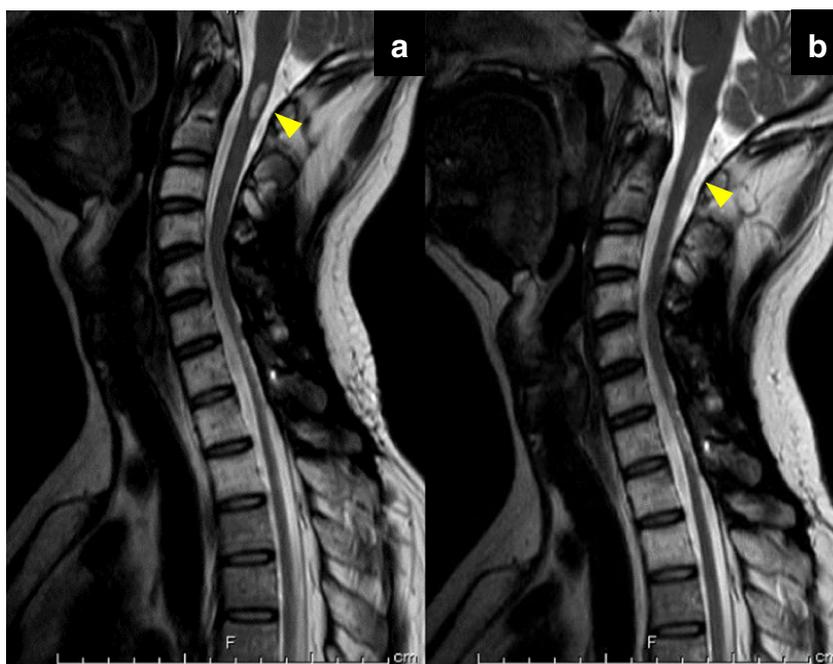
Magnetic resonance imaging showing a new bulbar lesion after alectinib discontinuation (a; sagittal plane view of T2-weighted image). Four months after alectinib rechallenge therapy, the lesion had disappeared (b; sagittal plane view of T2-weighted image). Arrowheads indicate metastatic lesions
